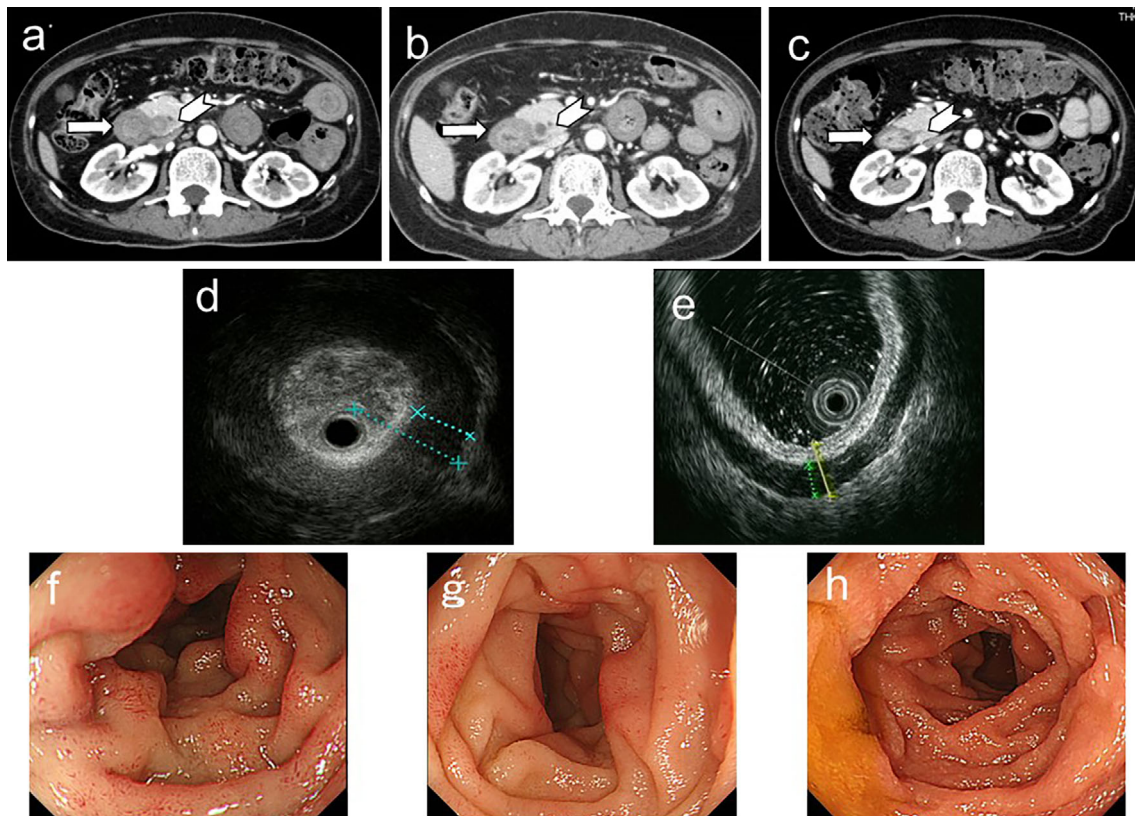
Contrast-enhanced computed tomography (CT) findings (a-c) and endoscopic ultrasound (EUS) findings of the duodenum (d-e), upper gastrointestinal endoscopic examination findings (f-h). (a) CT revealed the thickening of the gastroduodenal mucosal wall (arrow), and (d) EUS of the duodenum revealed extreme thickening of the mucosal and muscular walls. (c) (e) Both findings were improved after steroid therapy. In contrast, (b) dilation of the bile duct (arrow head) and (g) narrowing of the lumen of the second part of duodenum diminished before steroid therapy. (a) (d) (f) On admission, (b) (g) five days before steroid administration and (c) (e) (h) two weeks after steroid administration.
